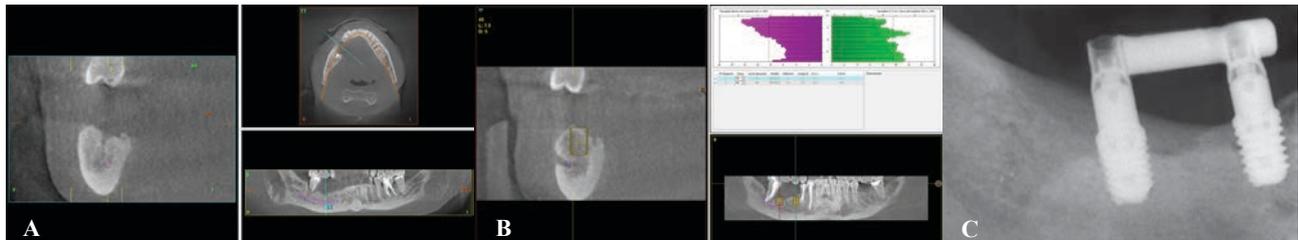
(A) CBCT image for treatment planning showing the 100% regeneration of bone volume. (B) Planning the position of the dental implants (C) Image of the immediately-loaded dental implants. The extraction socket of the lower right second molar can be observed. The post-extraction alveolus was treated with Endoret (PRGF) without any secondary effects or complications.
